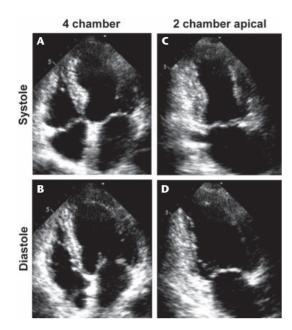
Apical 4- and 2-chamber echocardiographic images in diastolic and systole of the patient obtained on admission.
